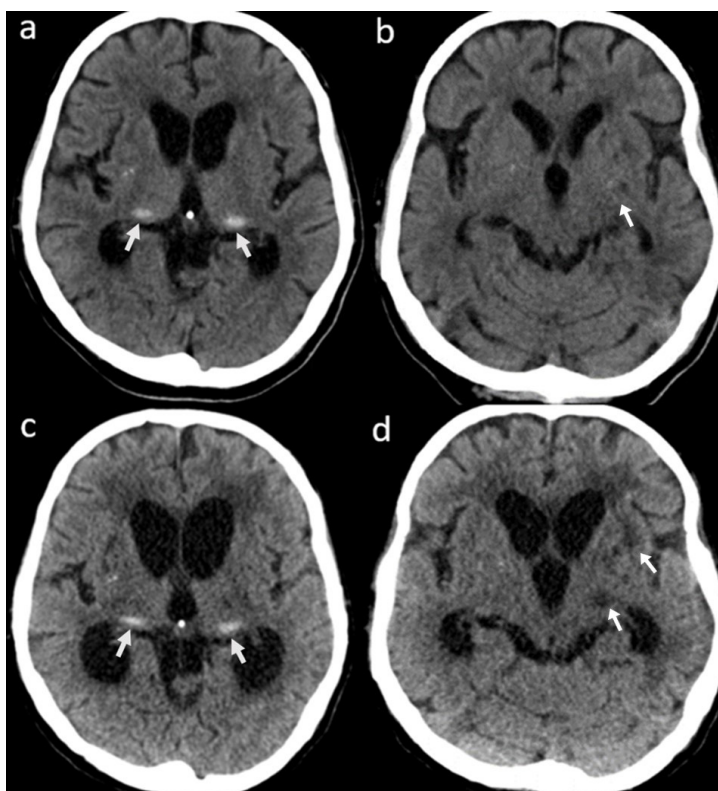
Brain CT images taken during index symptom and at onset of deterioration. All images are plain CT images. (a and b): Acquired from index event during initial presentation for chorea. (a). Bilateral symmetrical hyperdensities over both thalami signifying pulvinar calcification (arrows) are clearly seen along with subtle hydrocephalus. (b). A few ill-defined hypodense lesions most prominently in the left lentiform nucleus (arrow) can be appreciated. These were initially reported as infarcts. (c and d): Acquired four months later during acute deterioration. (c). Bilateral thalamic pulvinar calcification (arrows) are still present and are relatively unchanged. Additionally, the presence of adjacent hypodensities [not previously seen in (a)] suggest further thalamic involvement. Worsening hydrocephalus is appreciated as evidenced by increased dilatation of frontal and occipital horns of the lateral ventricles relative to (a). Periventricular hypodensities seen are likely to represent CSF seepage, suggesting a relatively acute process. (d). previously seen areas of hypoattenuation are slightly more conspicuous and are accompanied by new hypodense lesions (arrows) in the left lentiform nucleus, thalamus, and internal capsule. These may represent cryptococcomas or lacunar infarcts arising from a vasculitic process driven by cryptococcal infection. Further ballooning of the third ventricle indicates worsening hydrocephalus.
